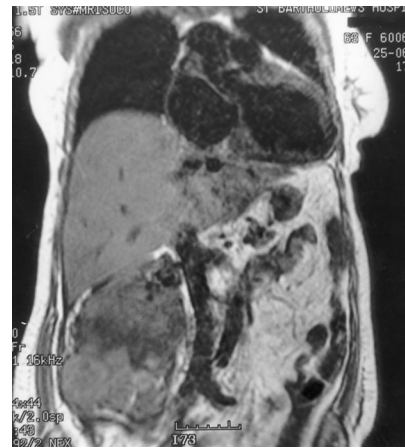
T1-weighted magnetic resonance image of a coronal section through the abdomen showing a large tumour in the right kidney.
